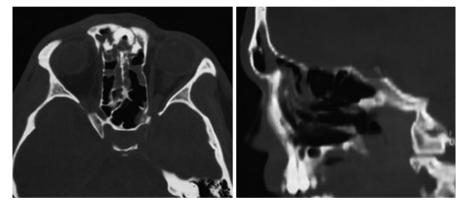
Axial and coronal CT views demonstrating opacification of the frontal sinuses with associated fractures. Although not apparent in the axial view, the sagittal reformatted view demonstrates apparent anatomic patency of the frontal outflow tract despite blood and soft tissue edema
